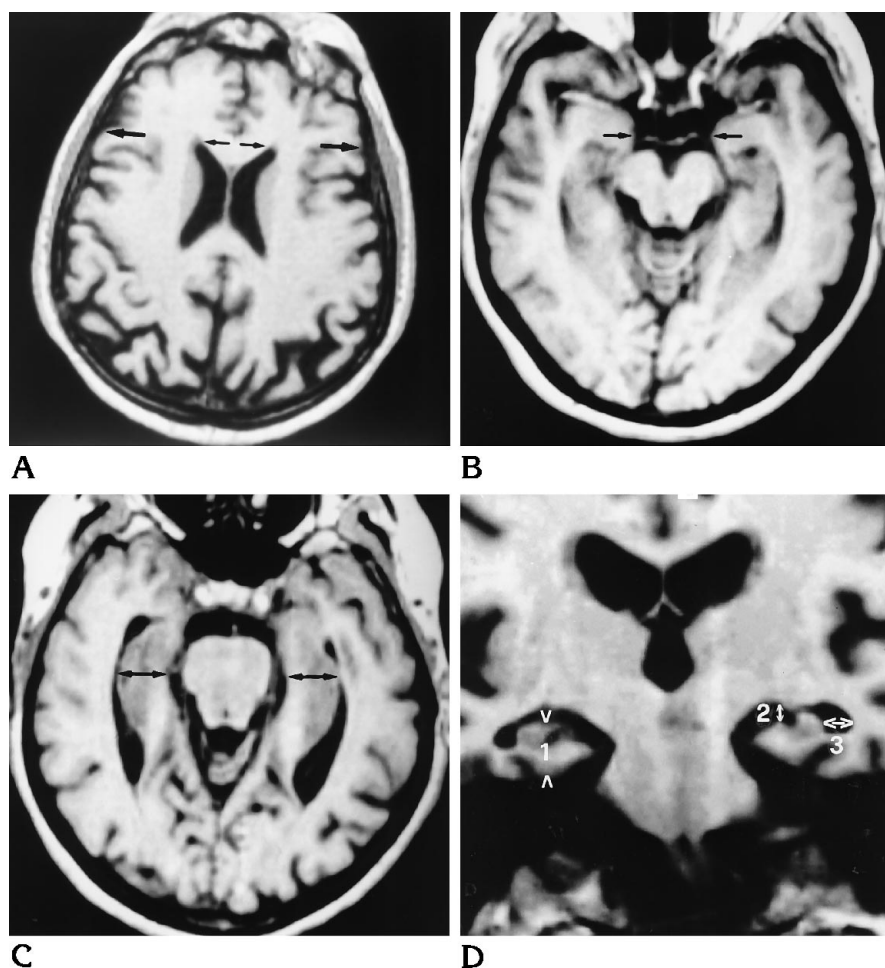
Axial (A–C) and coronal (D) three-dimensional gradient-echo MR images (10/4/2, 10° flip angle) of a patient with Alzheimer disease. The width between the frontal horns of the lateral ventricles (*smaller arrows*) and the cranial width (*larger arrows*) (bifrontal index) are shown in A; *arrows* in B indicate interuncal distance; *arrows* in C show minimum thickness of the medial temporal lobe; D shows hippocampal height (1), width of the choroid fissure (2), and width of the temporal horn (3).
